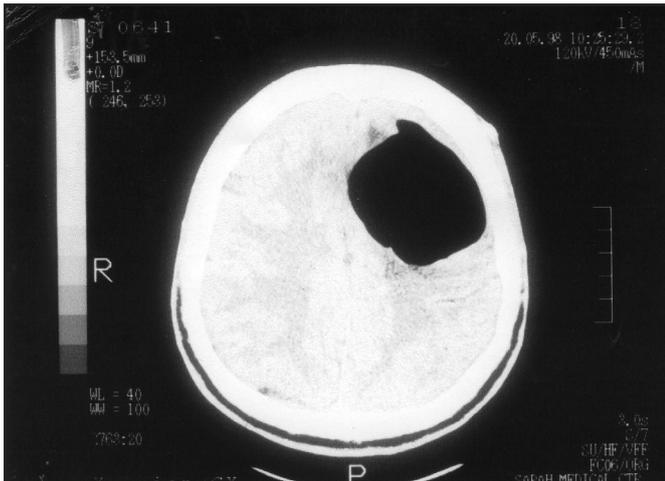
CT scan revealing a large pneumocephalus.
